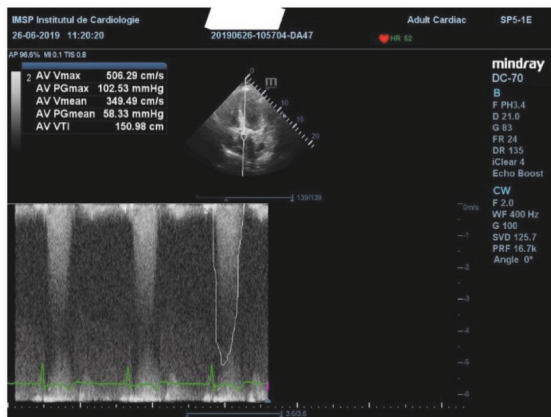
Echocardiography, patient No 1
